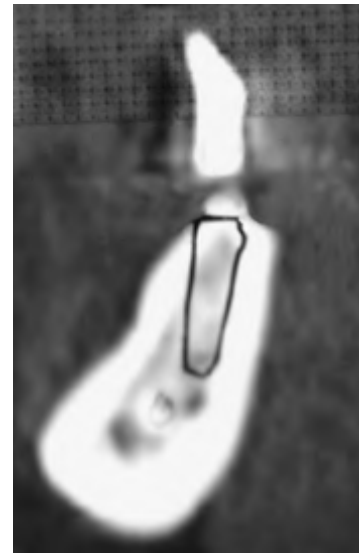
This is an image of a CT cross section of this patient's edentulous mandible. The CT scan was made with a duplicate denture in place, where the denture teeth were coated with barium sulfate. The radiopacity at the top of the image corresponds to an incisor, and its position relative to the potential implant site can be assessed. This location had adequate bone available for implant placement.
